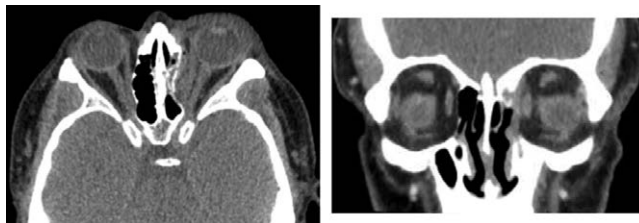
Axial and coronal CT images immediately after injury demonstrating moderately comminuted fracture of the medial wall of the left orbit with depression of fracture fragments into the left ethmoid air cells.
